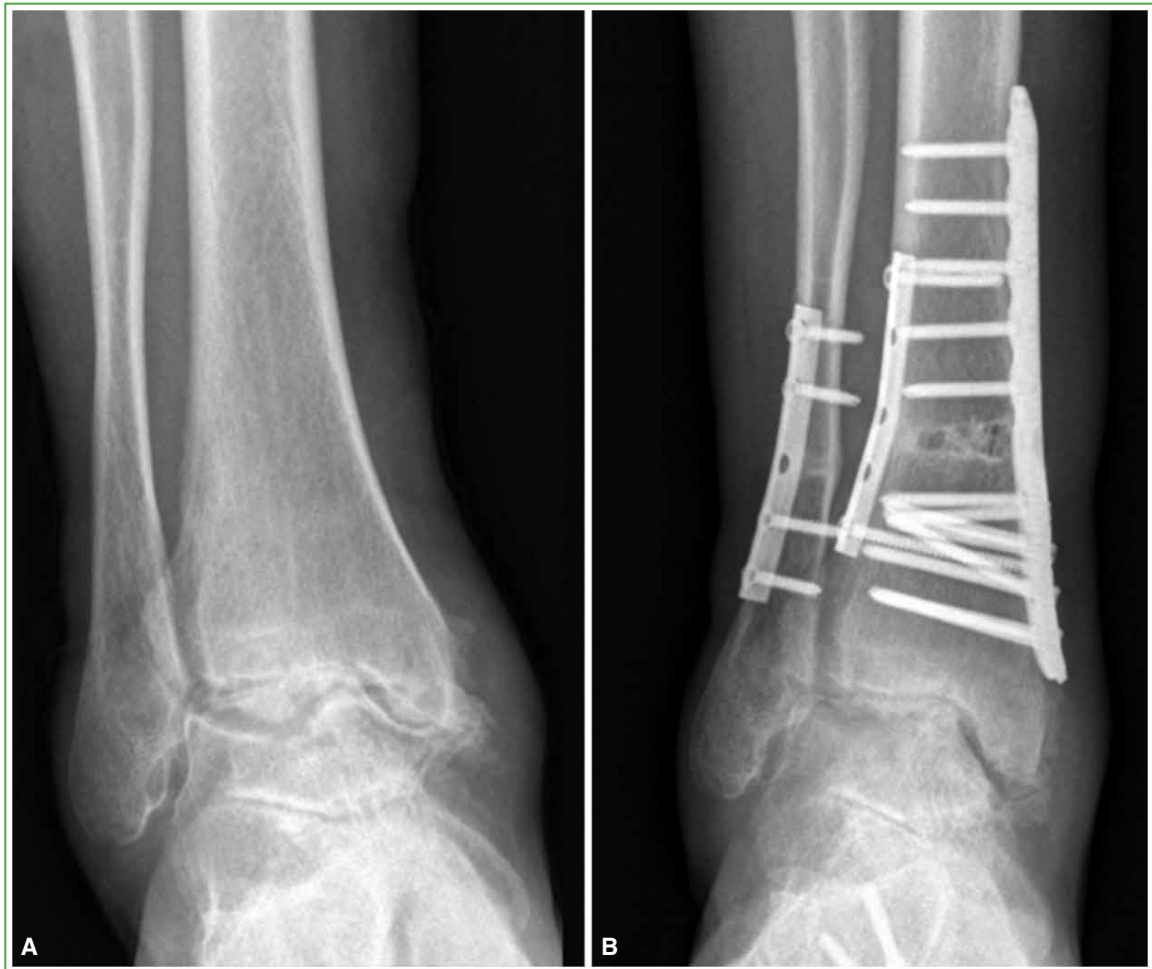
Takakura Stage IIIB. A. Preoperative ankle radiograph, AP view. B. Anteroposterior ankle radiograph, 2 years after internal supramalleolar opening-wedge valgus osteotomy.
